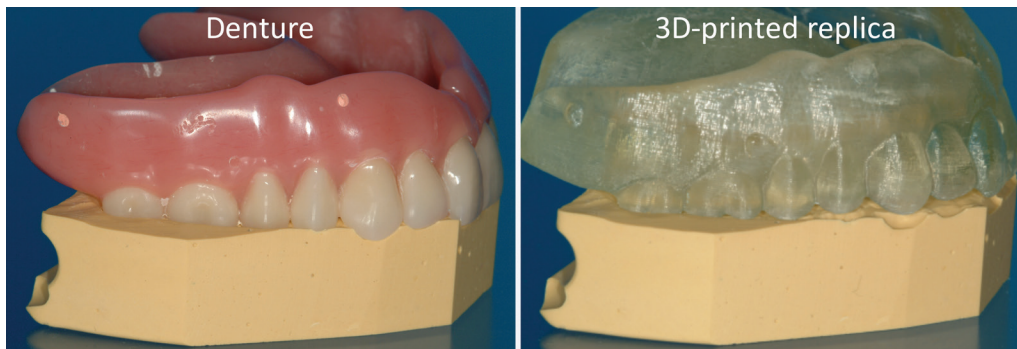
Left: Denture fitted on a stone platform. Right: The 3D printed model of the denture derived from cone-beam CT (0.4-mm section thickness) does not fit the platform. (Courtesy of Lambert J. Stumpel, DDS, San Francisco, Calif.)
